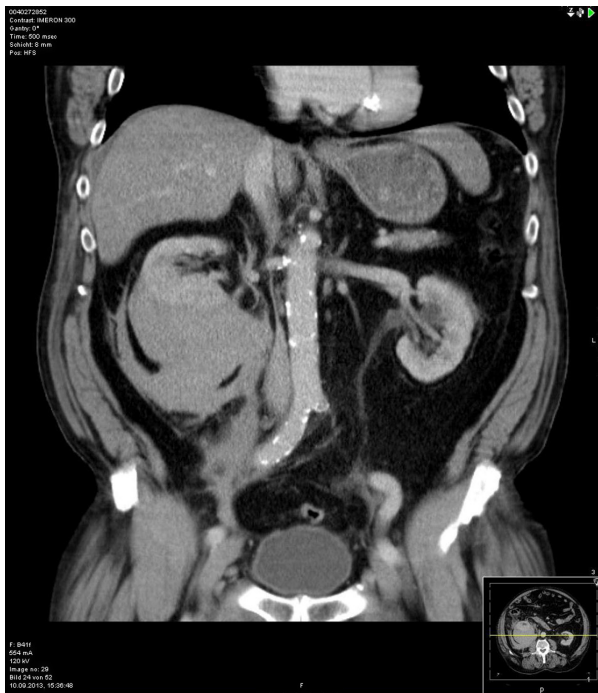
CT scan of large perirenal hematoma.
